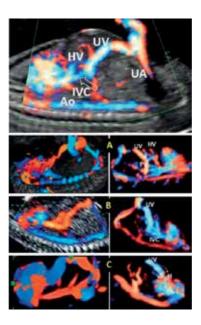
The upper image presents the normal appearance of ductus venosus in 2D color Doppler imaging. (A–C): Agenesis of ductus venosus: with hepatic (A), caval (B) and cardiac (C) drainage. UV, umbilical vein; IVC, inferior vena cava; H, heart; HV, hepatic veins; UA, umbilical artery; PV, portal vein; Ao, aorta.
